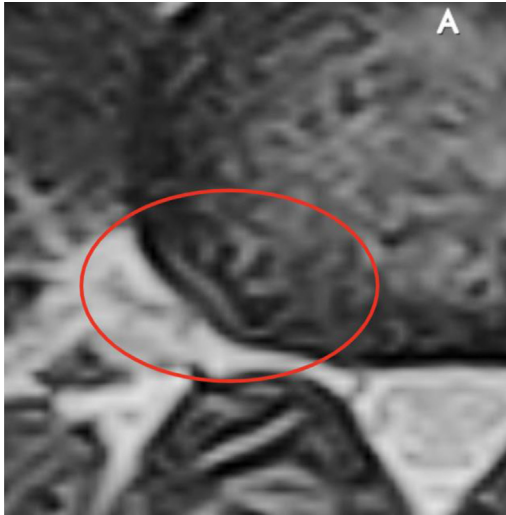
Magnified T2 Axial MRI image of right foraminal HIZ demonstrating structural changes 1-month postintradiscal LR-PRP delivered precisely into the region with a curved intradiscal catheter.
